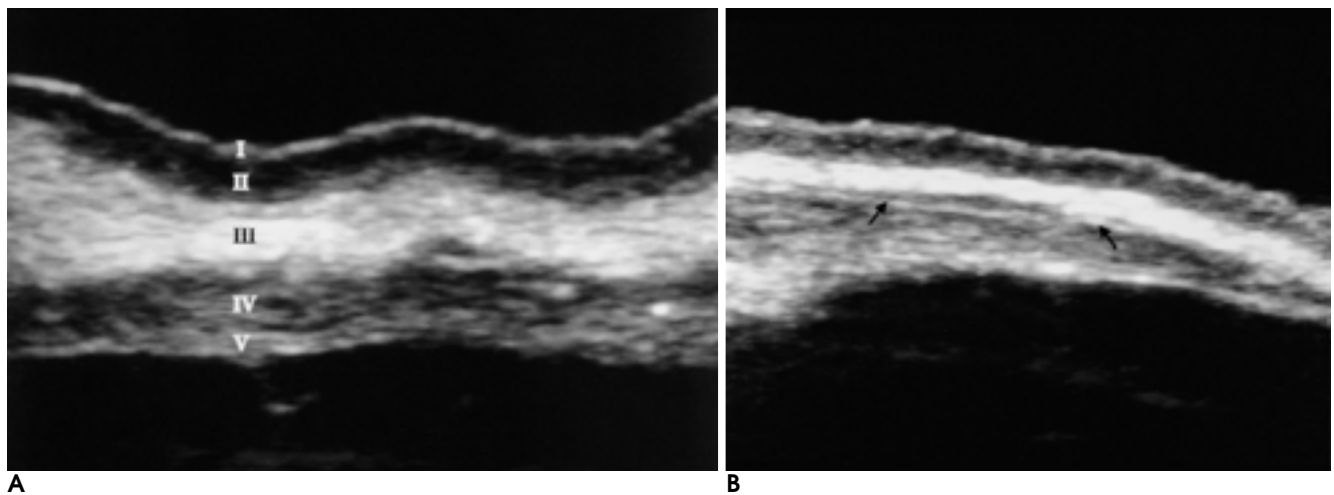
Ultrasonograms showing five (A) or six (B) layers of normal gastric walls, obtained by compound imaging technique. (A) Five layers consist of thin echogenic interface (I), hypoechoic mucosa (II), thick hyperechoic submucosa (III), hypoechoic muscularis propria (IV) and hyperechoic subserosa or serosa (V). (B) Note the echogenic line within muscularis propria layer (arrows), which indicates intermuscular connective tissue .
